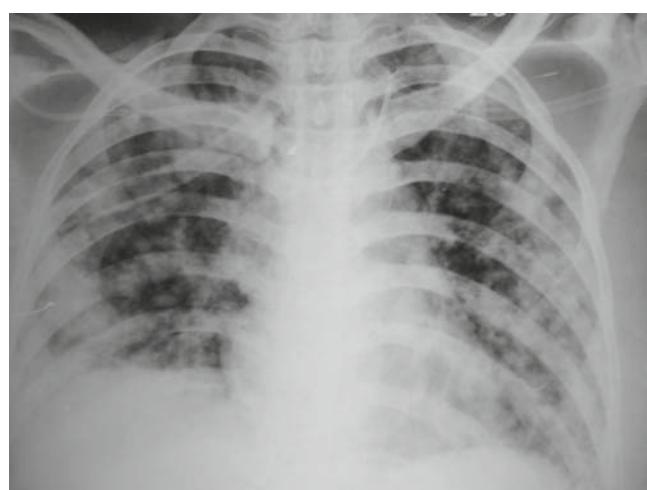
On day 6, chest X-ray showed pulmonary edema, as well as showing that the tip of the CVC had spontaneously migrated to the contralateral internal jugular vein
